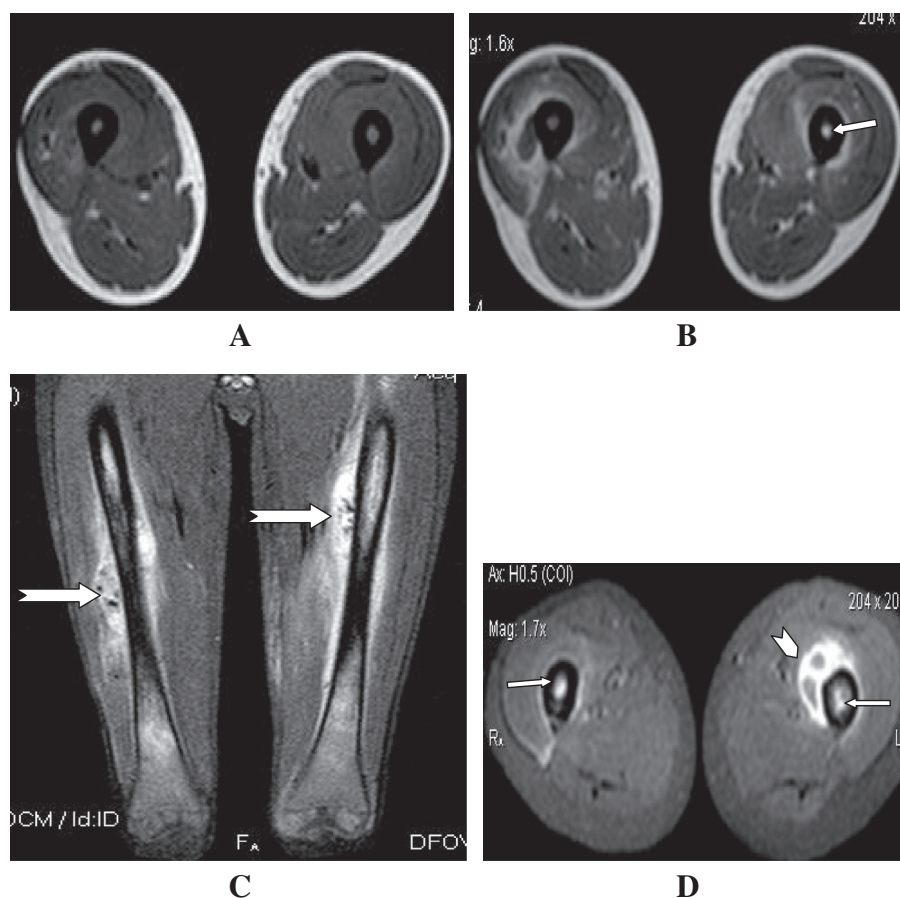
MRI of bilateral femoral multifocal osteomyelitis. (A) Axial T1w. (B) Post-contrast axial T1w. (C) Coronal STIR. (D) Post-contrast axial T1w. Fat sat sequences, showing patchy enhancing medullary foci (arrows) and parosseous extensive soft tissue edema (notched arrows) and ring enhancing collections (chevron).
